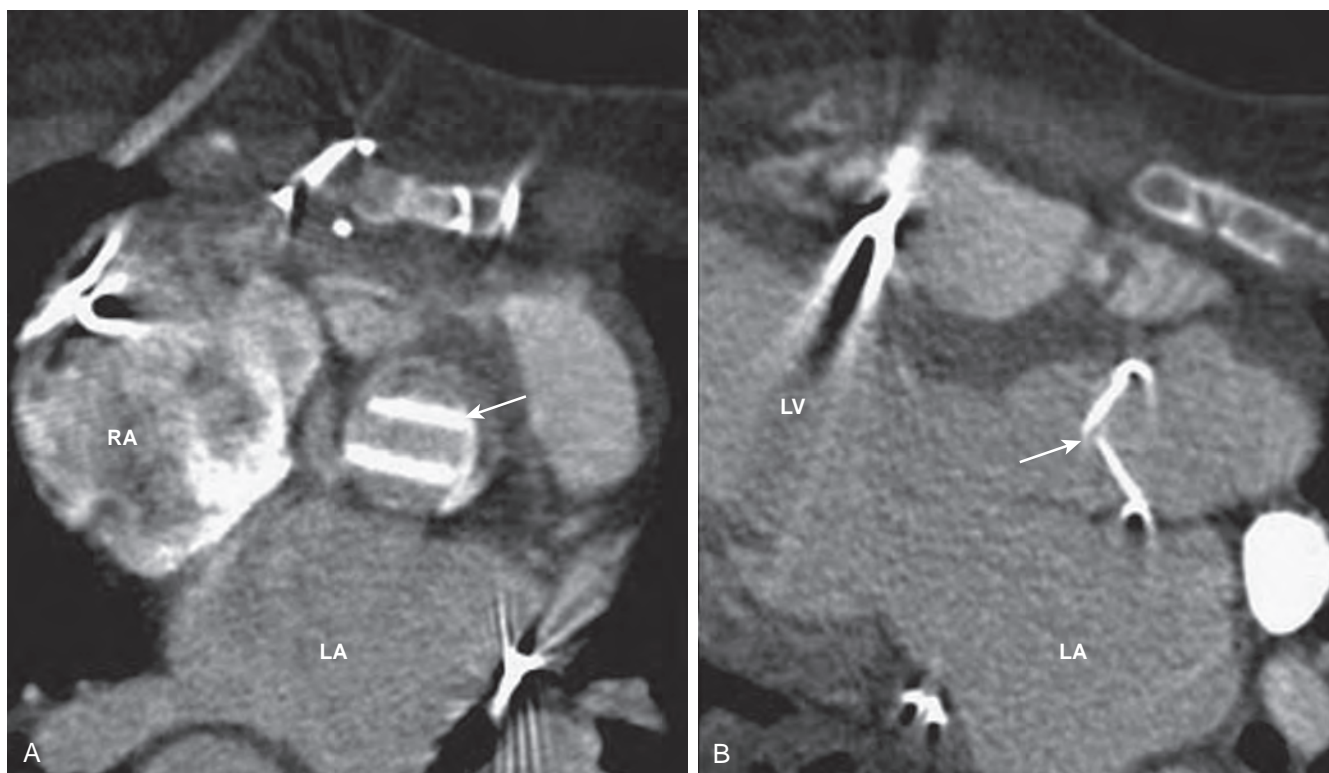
Computed tomography angiography of an aortic mechanical valve (arrow) in short-axis view (A) and three-chamber view (B). LA, Left atrium; LV, left ventricle; RA, right atrium.
